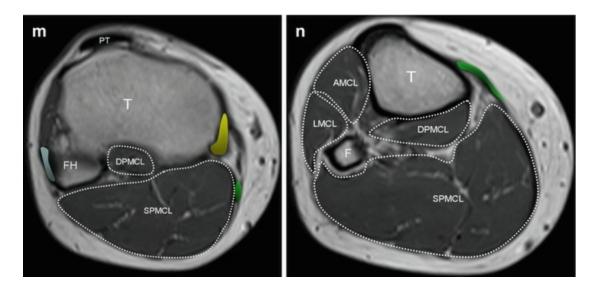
(a) Axial T1-weighted MRI shows the long head of the biceps femoris arising together with the semitendinosus tendon (red) on the inferomedial aspect of the ischial tuberosity (IT). Note also the semimembranosus tendon (vellow) on the superolateral aspect of the IT. F femur. (b) In the plan distal to A, the long head of the biceps femoris (pink), semitendinosus (green), and semimembranosus (yellow) tendons are visible. Note that the semitendinosus muscle becomes bulbous distally in (c). F femur, IR ischial ramus. (d) Axial plan of the proximal middle third of the thigh shows the muscle bellies of the long head of the biceps femoris (pink) and semitendinosus (green). Note the semimembranosus muscle belly (vellow) distally in (e). F femur. (f) The three muscle bellies have about the same areas in the middle third of the thigh, and the short head of the biceps femoris tendon (blue) arises from the lateral lip of the linea aspera of the femur (*). The belly of this muscle is visible distally in (g). Note also the muscle bellies of the long head of the biceps femoris (pink), semitendinosus (green), and semimembranosus (yellow). F femur, MMC medial muscular compartment. (h) Bellies of the short (blue) and long (pink) heads of the biceps femoris, semitendinosus (green), and semimembranosus (yellow) muscles in the distal third of the thigh. Note the semitendinosus tendon (green) distally in (i) and (j). F femur, P patella, AMC anterior muscular compartment, QTquadriceps tendon, SPMCL superficial posterior muscular compartment of the leg. (k) Axial plan of the knee shows fused fibers of the long and short heads of the biceps femoris (light blue), semitendinosus (green), and semimembranosus (vellow) tendons. PT patellar tendon. (1) Axial plan of the knee shows the insertions of the semimembranosus tendon (direct arm; vellow) on the medial tibial condyle. The insertions of the biceps femoris (light blue) on the lateral side of the fibular head (FH) and the anterior arm of the semimembranosus tendon (yellow) are visible in (m). T tibia, DPMCL deep posterior muscular compartment of the leg. (n) Axial plan of the proximal leg shows the insertions of the semitendinosus tendon (green) on the superomedial surface of the tibia (T). At its insertion, the semitendinosus tendon lies posterior to the tendon of the sartorius and inferior to that of the gracilis. These three tendons form the pes anserinus. F fibula, AMCL anterior muscular compartment of the leg, LMCL lateral muscular compartment of the leg
